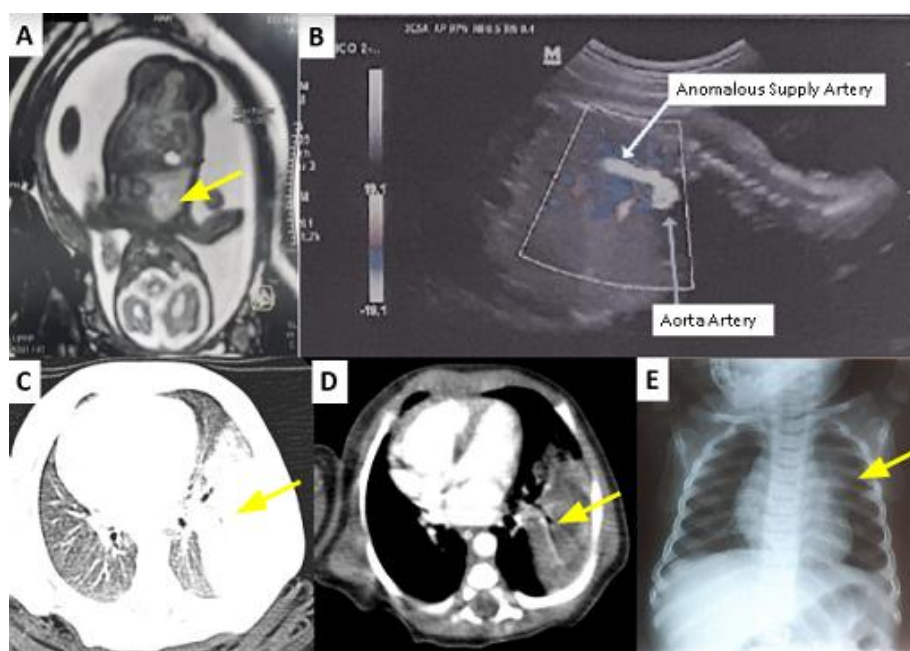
A: Fetal Magnetic Resonance Imaging. B: USG demonstrating anomalous vessel. C: Chest computed tomography showing a pulmonary base lesion; D: Computed tomography showing a lesion in the middle third of the lung, in segment IV. E: Chest X- Ray.
